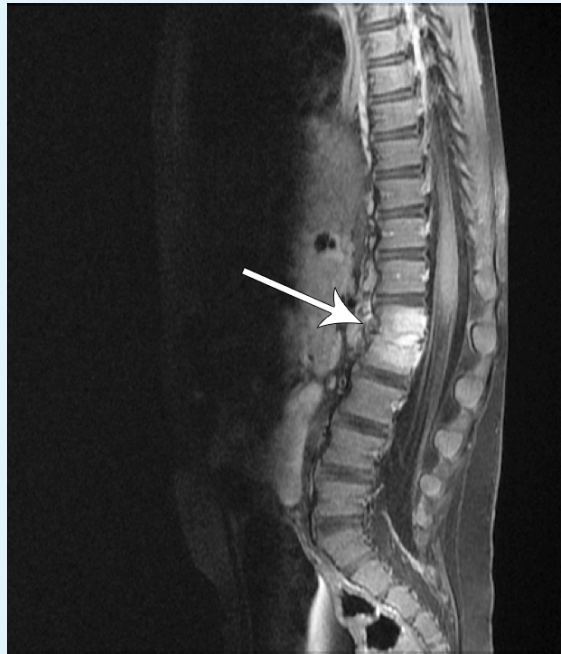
MRI spine with GAD showed a discitis at L1-2 without significant compromise of the spinal canal, and a very small epidural abscess. GAD - Gadolinium
